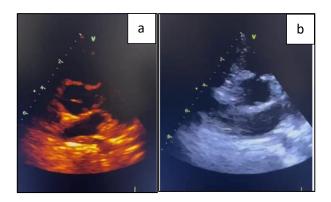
(a and b): 2D echocardiogram image of a significant-sized thrombus located in the left atrial appendage.
